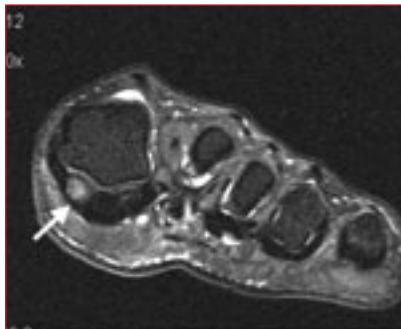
MRI of the sesamoids showing bone marrow oedema of the medial sesamoid compatible with a bone stress injury.
